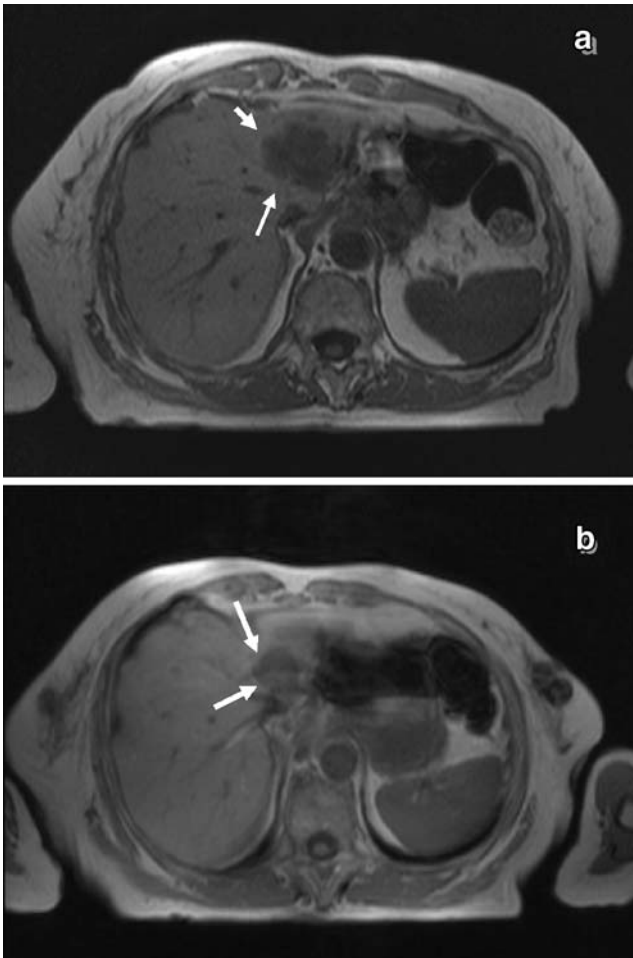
a, b A 51-year-old patient (CRC: T3, N1, M1) demonstrating colorectal liver metastases regression after a three-session TACE treatment course. a Pre-treatment non-contrast axial T1-weighted MRI showing a left lobe lesion (*arrow*). b Post-embolization MRI using the same imaging technique after the third session, showing notable size reduction of the tumour (*arrow*). No newly developed lesions were detected
